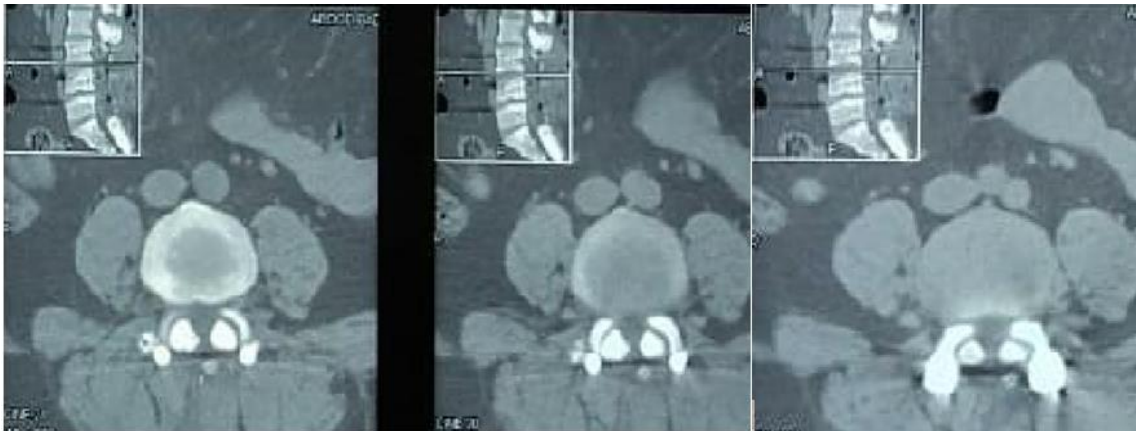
CT LSS axial cuts of L3-4 facet joints of patient who needed lumber fixation after 1 year; showing that previous facet bone resection in 1st operation was less than 50%.
